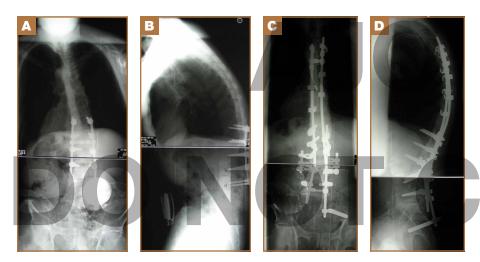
(A) Preoperative anteroposterior radiograph. (B) Preoperative lateral radiograph shows prior lumbar fusion and sagittal decompensation. (C) Postoperative anteroposterior radiograph. Note outrigger rods at level of pedicle subtraction osteotomy. (D) Postoperative lateral radiograph shows improved sagittal alignment.
